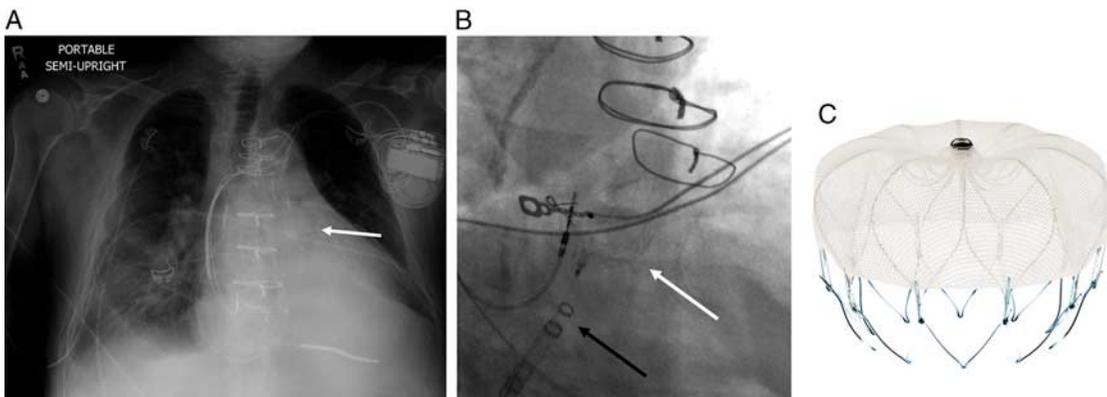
Nonsurgical LAA exclusion: frontal radiograph (A) and magnified angiogram view (B) of Watchman LAA occluder device (used with permission) (C). Note the fine metallic mesh umbrella in the expected location of the LAA (white arrow) and the delivery catheter on the magnified angiogram view during placement (black arrow). full color online
